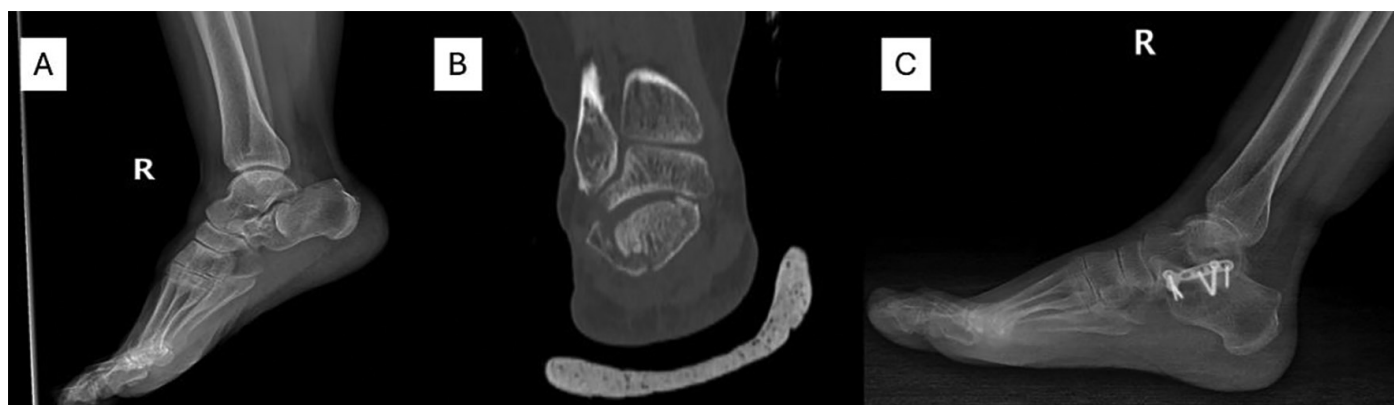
A patient operated on using the sinus tarsi approach. (A) Preoperative lateral X-ray image of the patient with a calcaneal fracture. (B) Coronal CT scan showing intra-articular comminution of the calcaneal fracture. (C) Postoperative lateral X-ray image showing fixation of the calcaneal fracture with a T-plate.
